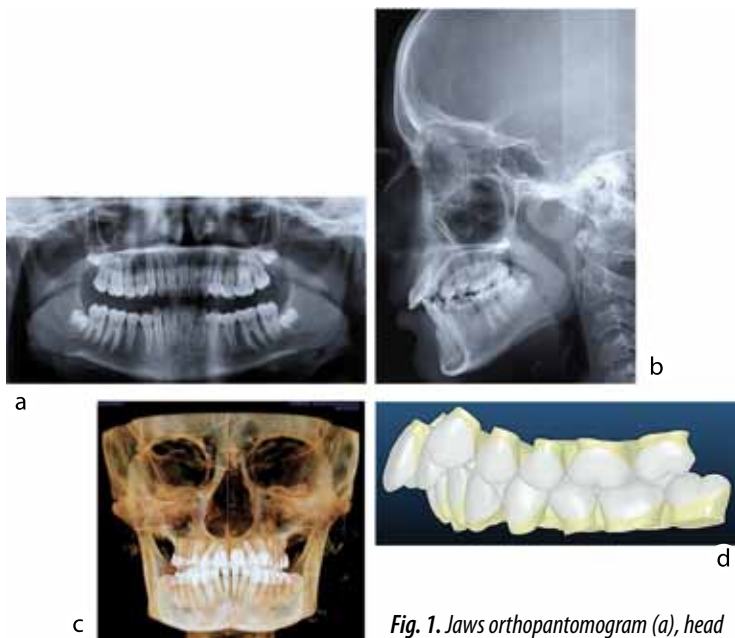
Jaws orthopantomogram (a), head telorentgenogram (lateral projection) (b), 3D panorama at FOV 8×15 in Unshaded VR mode (frontal projection) (c) and virtual diagnostic Set-Up model in the file "ORAPIX" 3Txxr 2.5.0 (Japan) (d); patient T with CTD, 16 y.o.
